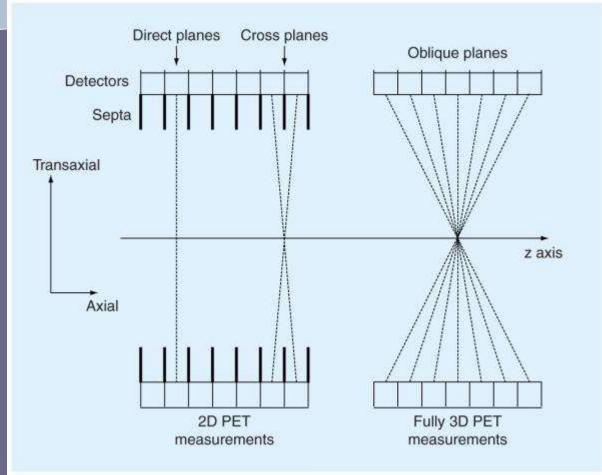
Tong S, Alessio AM, Kinahan PE. Image reconstruction for PET/CT scanners: Past achievements and future challenges. *Imaging Medicine*. 2010; 2(5): 529-545.
